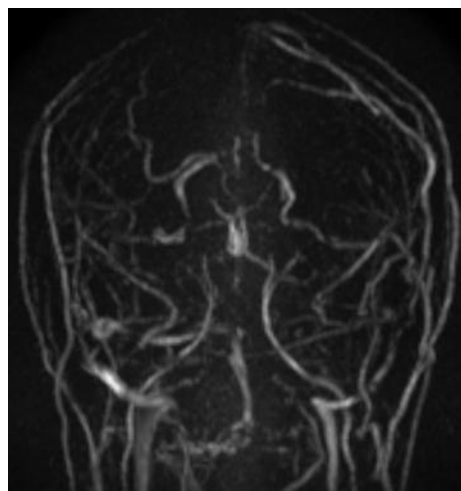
MRI Brain of same patient showing sagittal sinus flow void suggestive of progressive CVT.
